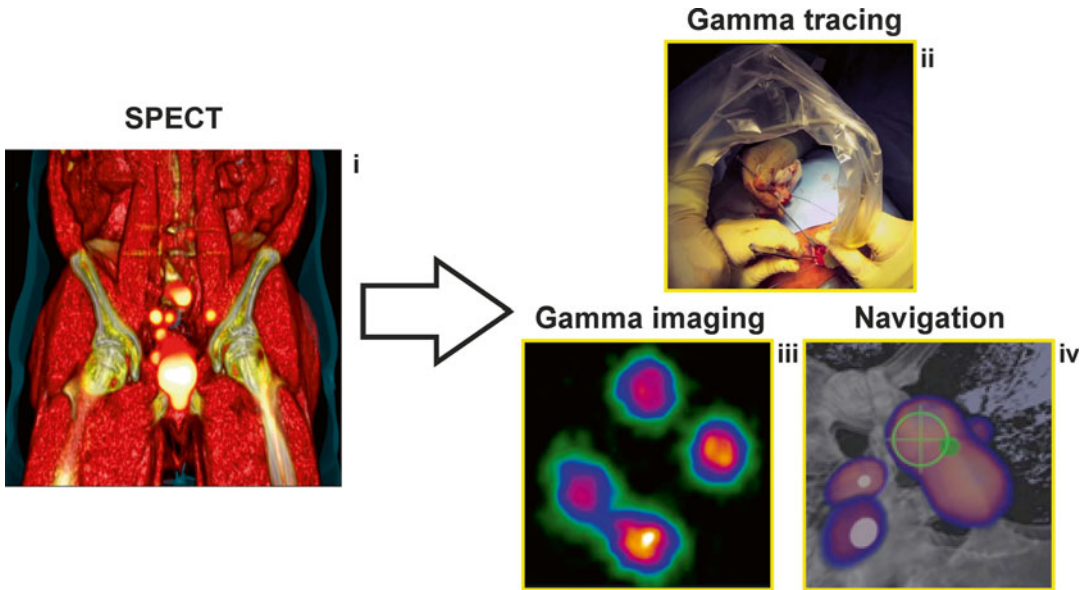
Application of γ -emitters in RGS. (i) Whole body nuclear imaging by SPECT; (ii) intraoperative gamma tracing with acoustic gamma probe; (iii) intraoperative gamma
